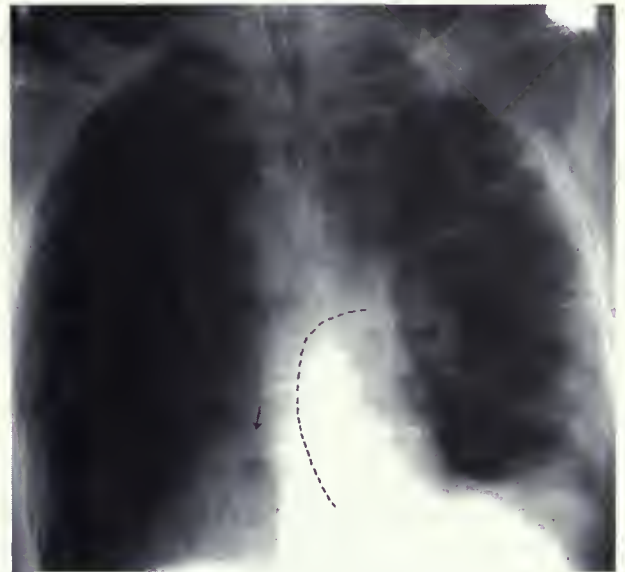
Chest radiograph obtained immediately after insertion of a pulmonary artery catheter (identical to radiograph shown in Figure 1). The catheter was inserted using the right internal jugular approach. The catheter entered the right ventricle through the tricuspid valve. Instead of entering the pulmonary artery, the catheter doubled back on itself and reentered the right atrium where its tip then lodged in the coronary sinus (arrow). The dotted line shows the typical path that a properly placed left pulmonary artery catheter would have taken.
